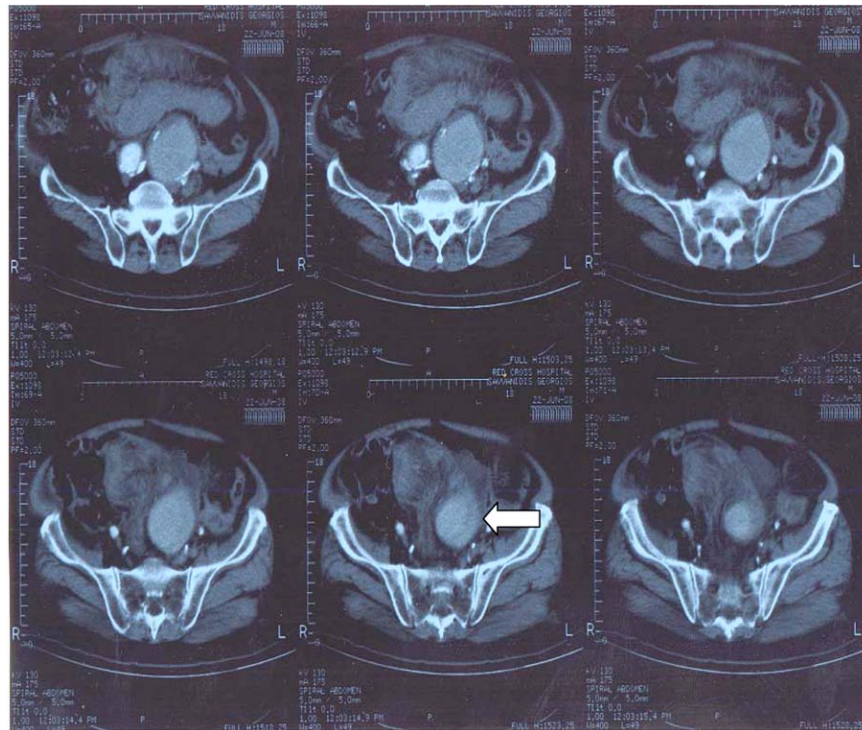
A CT scan showing the ruptured left iliac para-anastomotic aneurysm (arrow).
